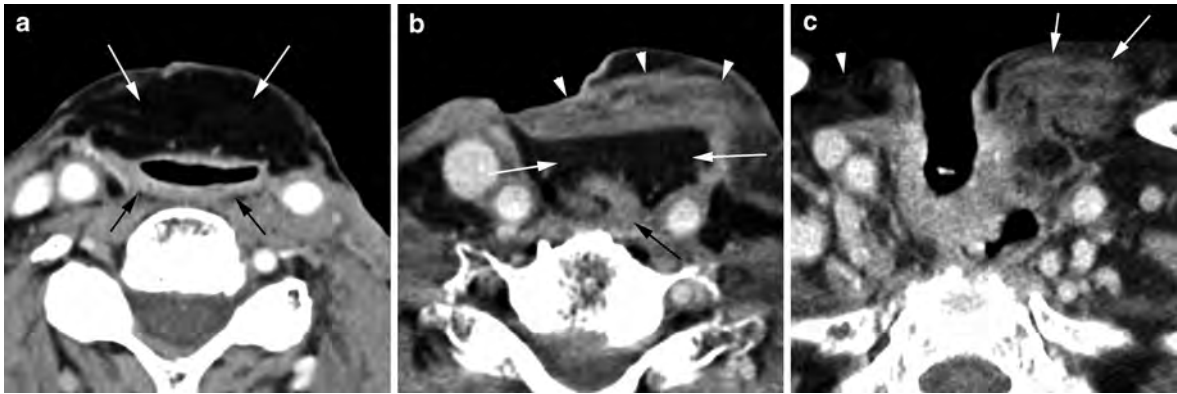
Sequential axial contrast-enhanced CT images extending from the mid-neck to thoracic inlet demonstrate the expected changes following total laryngectomy and partial pharyngectomy with pectoralis major muscle reconstruction of the neopharynx. At the mid-neck level, only fatty tissue (*white arrows* in a) is seen anterior to the smoothly walled appearing neopharynx (*black arrows* in a). More inferiorly, the muscular
